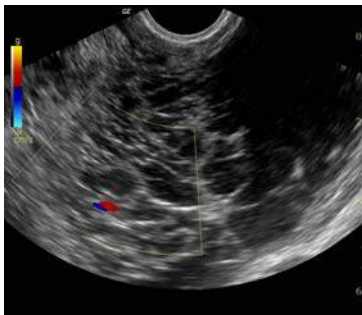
Same patient, Transvaginal color doppler scan.
